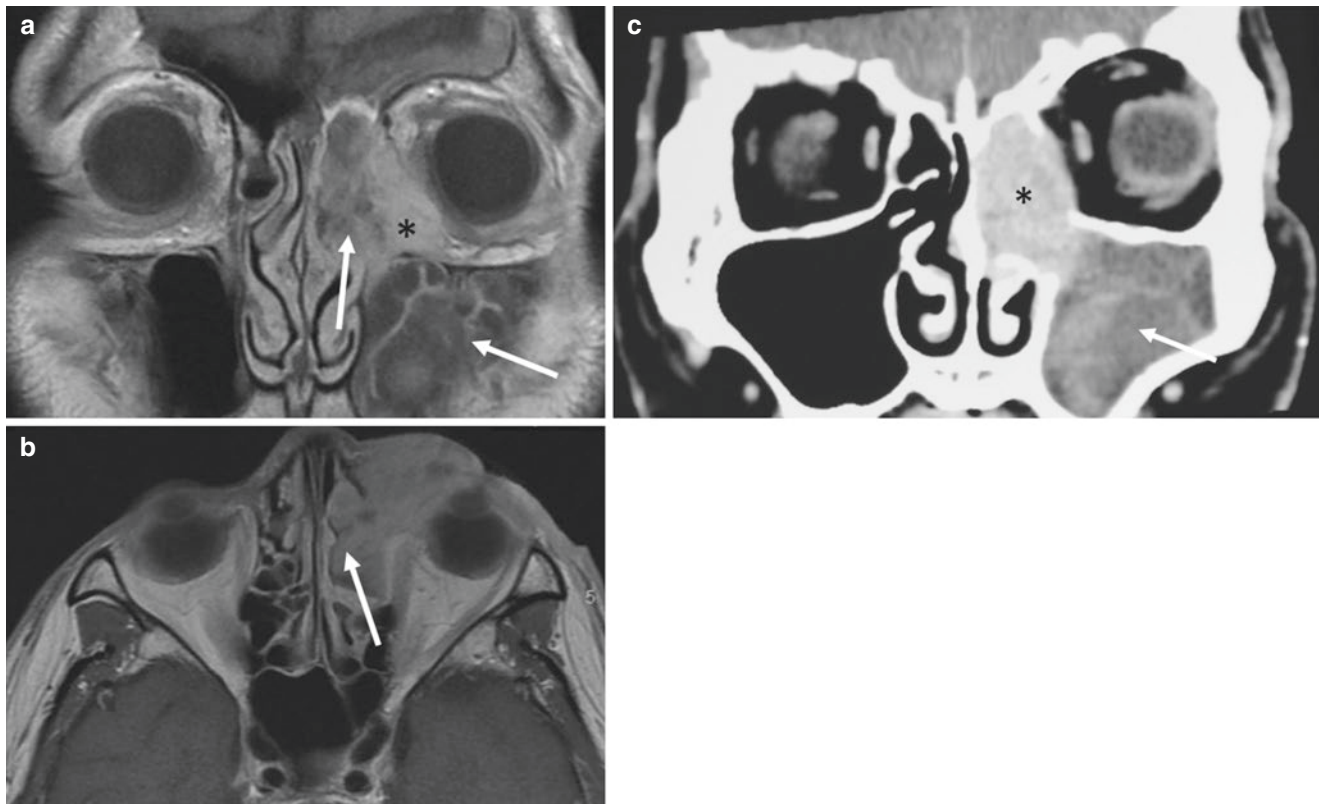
Coronal (a) and axial (b) contrast-enhanced T1w MRI and coronal CT (c) showing enhancing tumour extending from the left lacrimal fossa (*) involving also adjacent ethmoid sinus and medial maxillary sinus with retained secretions (white arrow), and mucosal thickening. Note the thinning/erosion of the medial orbital wall in coronal contrast CT
